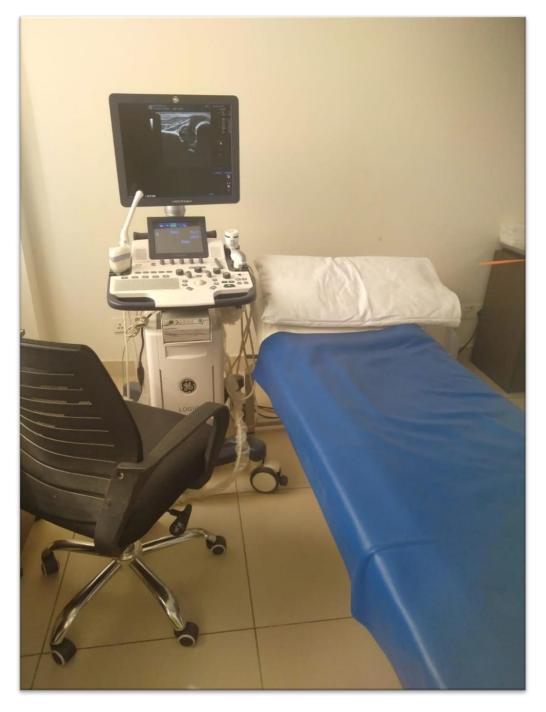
Toshiba Aplio 300, High Frequency Linear Probe 7.5 MHz Ultrasound Machine used in radiology department of National Institute of Child Health (NICH) Karachi.
